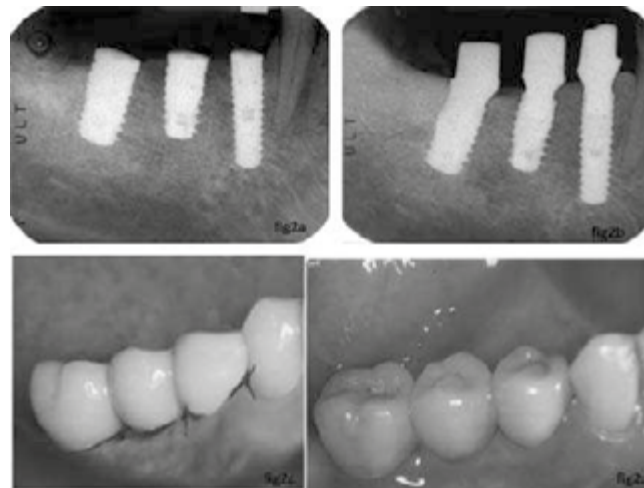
A) Immediate, post-operative peri-apical radiograph: three new implants were placed 50 days after the removal of the failed implants. The biologic distance among the different implants and the implants and the adjacent natural dentition was respected. B) Post-operative peri-apical radiograph with platform switched custom made abutments seated. C) Methacrylate provisional restorations were delivered within 24 hours the surgical placement of the implants D) Clinical view of the final restorations that were delivered 4 months following the implant placement
